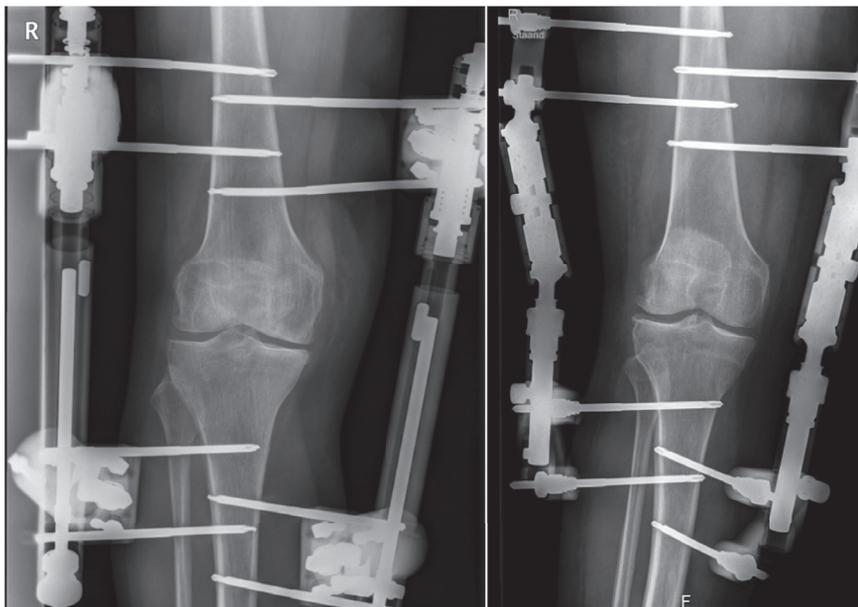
Radiographs of the concept (CD) device (left) and dedicated distraction (DD) device (right) in use. The surgical procedure for fixation of both devices is equal and performed with similar half pins.
